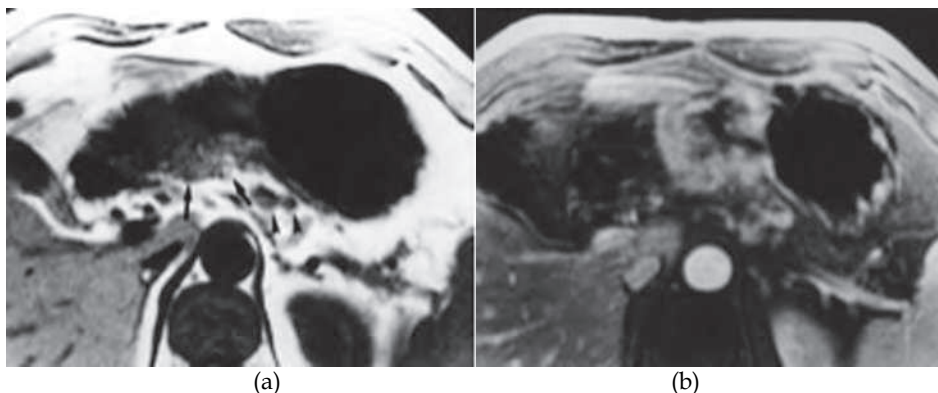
T3 Gastric Carcinoma. 54-year-old man. A, B. Axial unenhanced (A) and contrast-enhanced (B) T1-weighted MR images show concentric tumor with strong contrast enhancement in gastric body. Extraluminal nodule of gastric tumor and infiltration in adjacent fat (arrows, A) are well seen on A. Note few enlarged lymph nodes in left perigastric region (arrowheads, A) (Sohn, et al. 2000).
